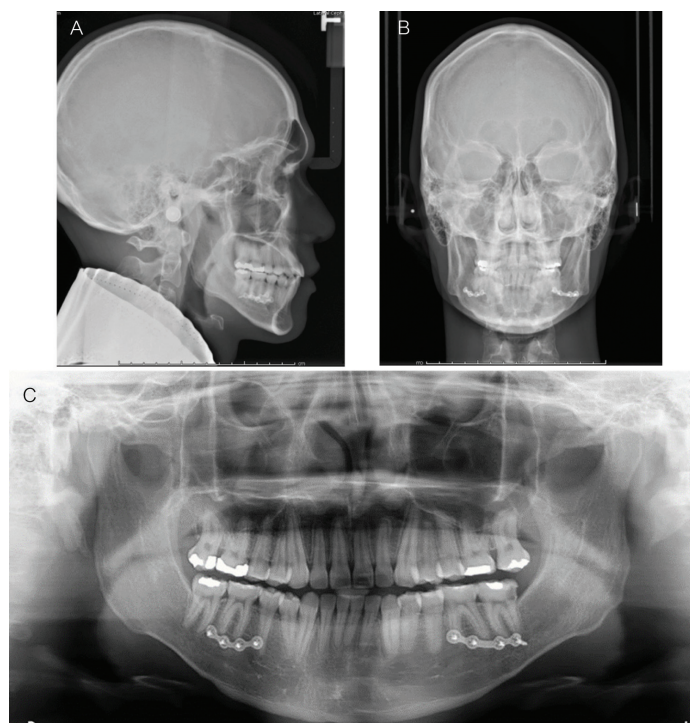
Immediate post-treatment (A) lateral cephalogram, (B) postero-anterior cephalogram, and (C) panoramic radiograph.
